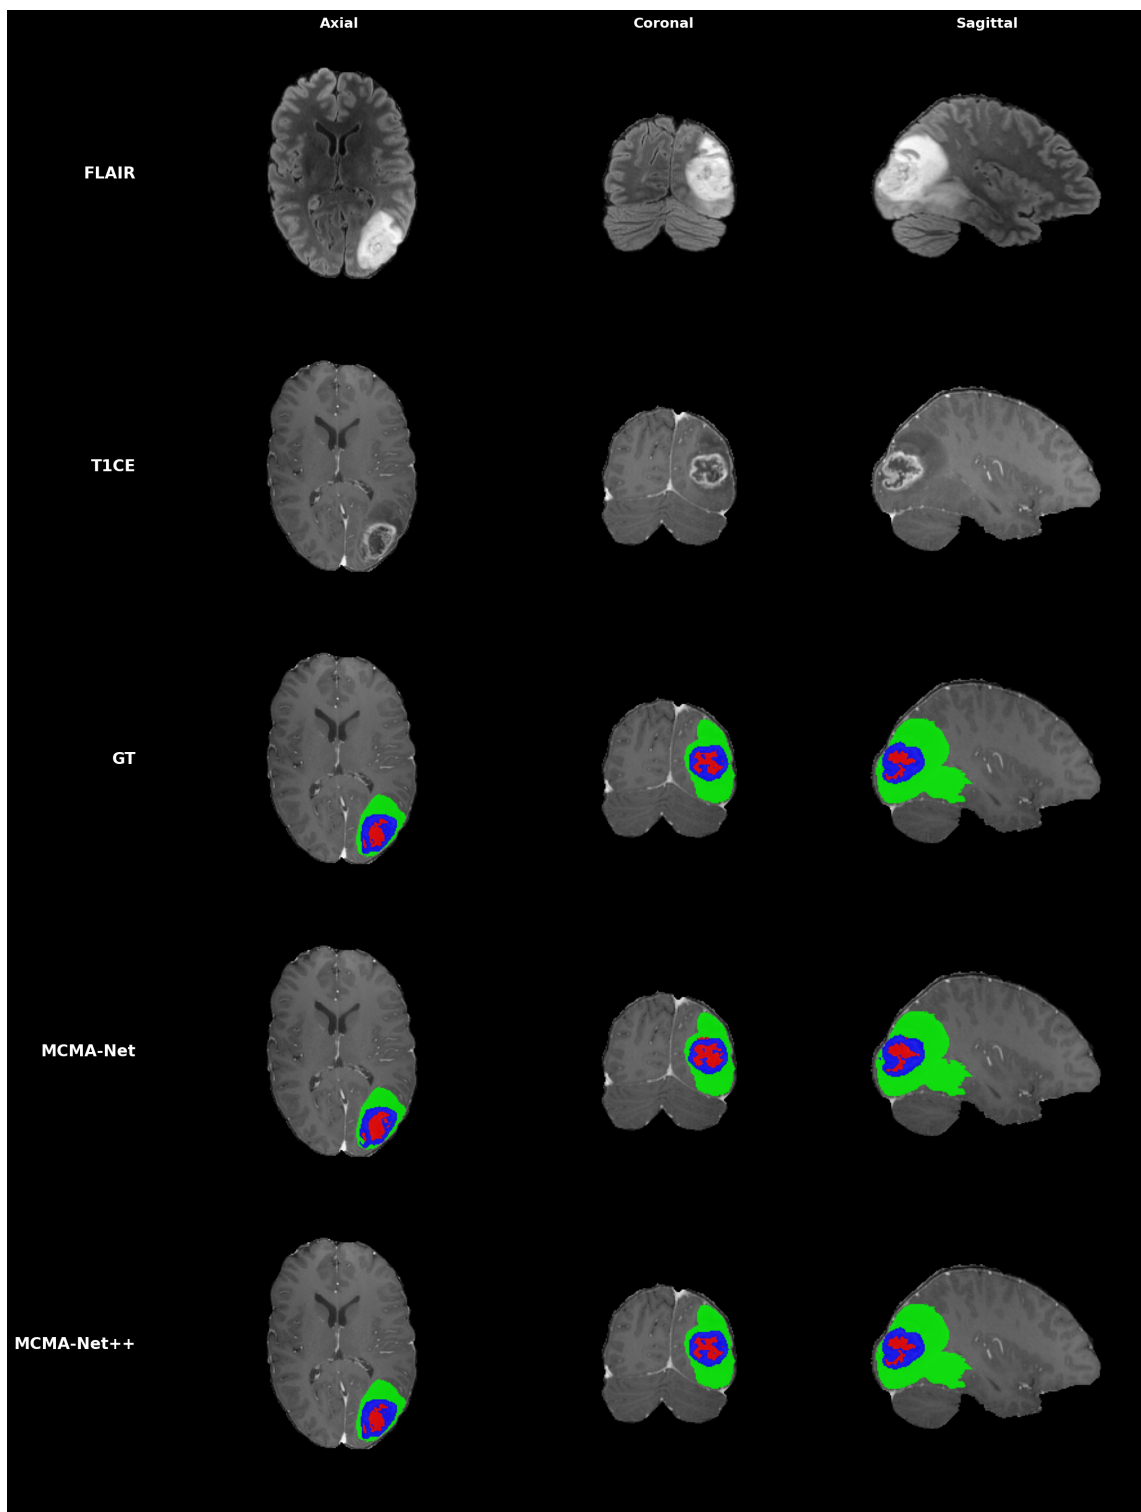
Qualitative comparison on BraTS 2021 case 00048 across three anatomical views. Rows show: FLAIR and T1ce modalities, GT annotations, MCMA-Net predictions, and MCMA-Net++ predictions. Color coding: green = ED, red = NCR/NET, blue = ET.
